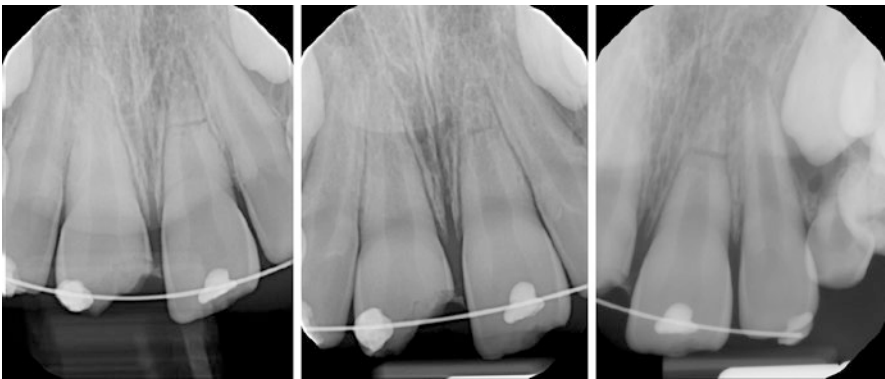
This is another case of a dental trauma to the permanent central maxillary incisors. The 10-year-old boy had been in a bicycle accident a few days before and a splint was placed at the emergency appointment. The right-hand-side central incisor suffered a complicated enamel-dentine fracture and the left-hand-side central incisor a horizontal root fracture in the apical third. Taking radiographs from different angles can be extremely useful in trauma cases to assess and identify root fractures
